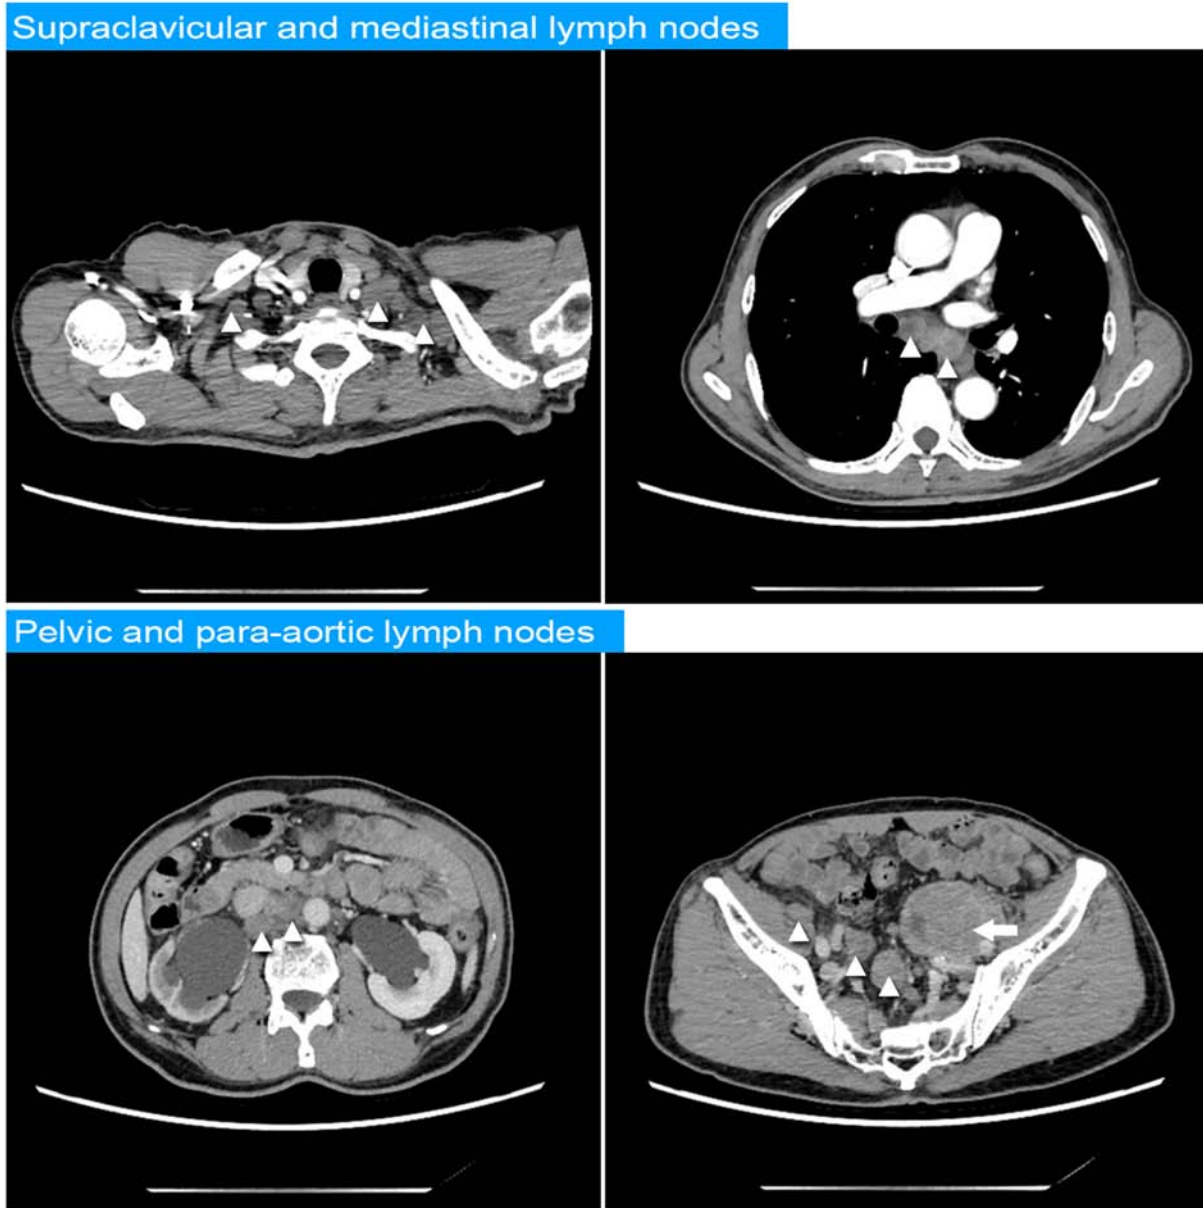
Generalized lymphadenopathy and the pelvic mass are shown on enhanced computed tomography arterial phase images; the arrow indicates the pelvic mass, and triangles indicate enlarged lymph nodes.
